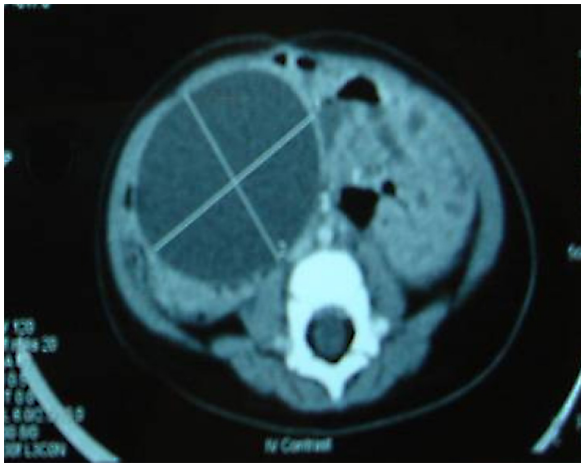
Abdominal computed tomography showing cystic mass occurring close to the bowel mesentery.
